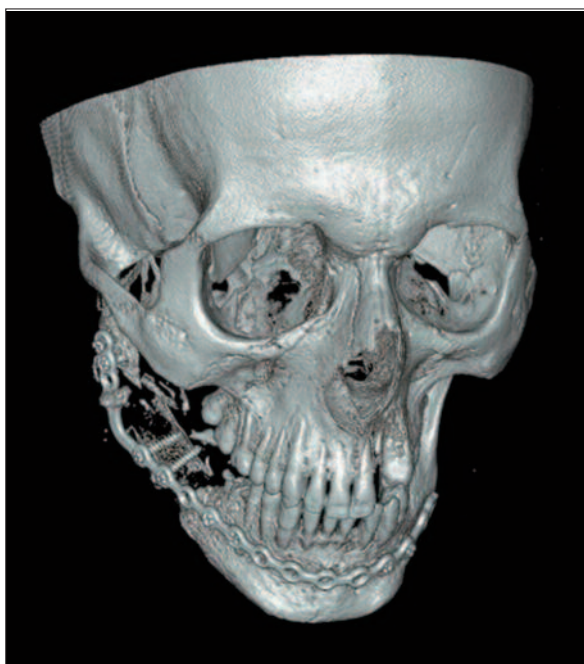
Graft resorption is seen on the control CT at 6 months in the patient, with no graft viability.
